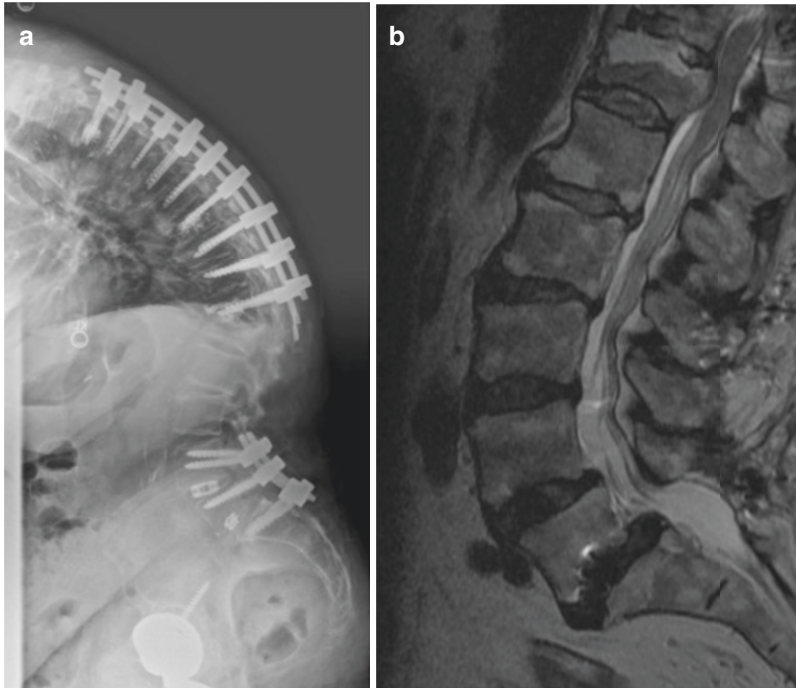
(a) Standing scoliosis film of 67 year old female with prior T4-T11 and L4-S1 fusion with new T12 compression fracture. (b) MRI lumbar without contrast demonstrating T12 compression fracture with retropulsion of T12 vertebral body causing moderate to severe spinal canal stenosis
